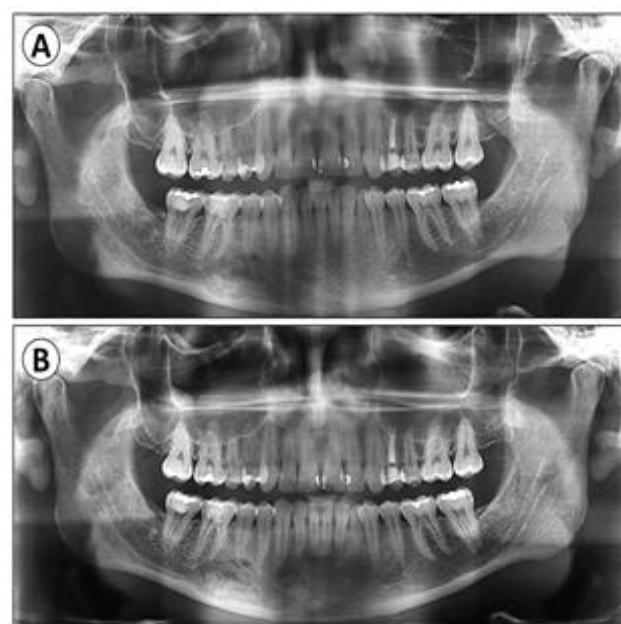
Radiographic follow-up. A - Postoperative panoramic radiograph at 14 days. B - Postoperative panoramic radiograph at 6 months.
